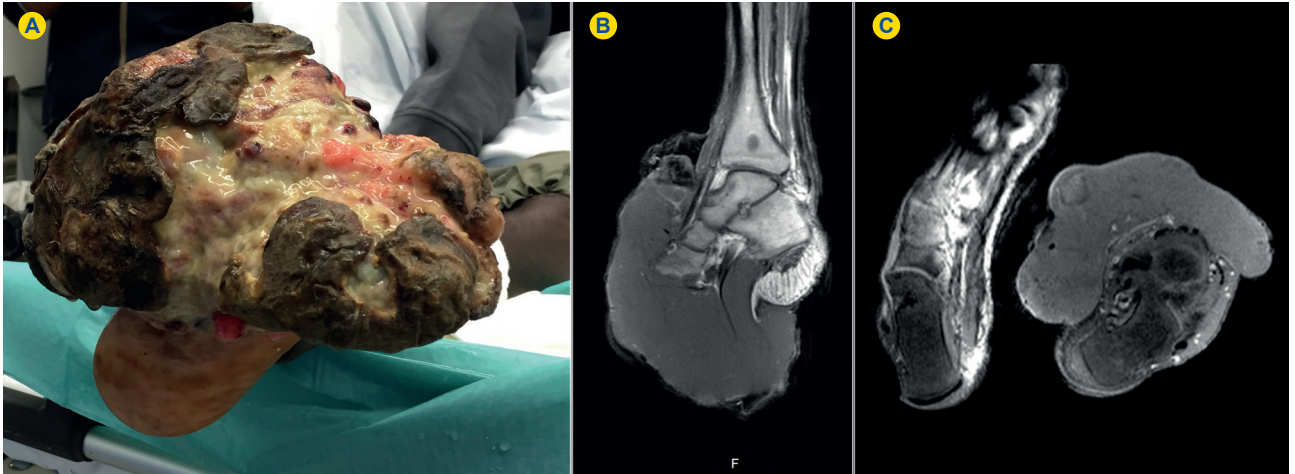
Ulcerated giant tumoral mass of the left foot (A); Sagittal and coronal MRI studies (B, C).
